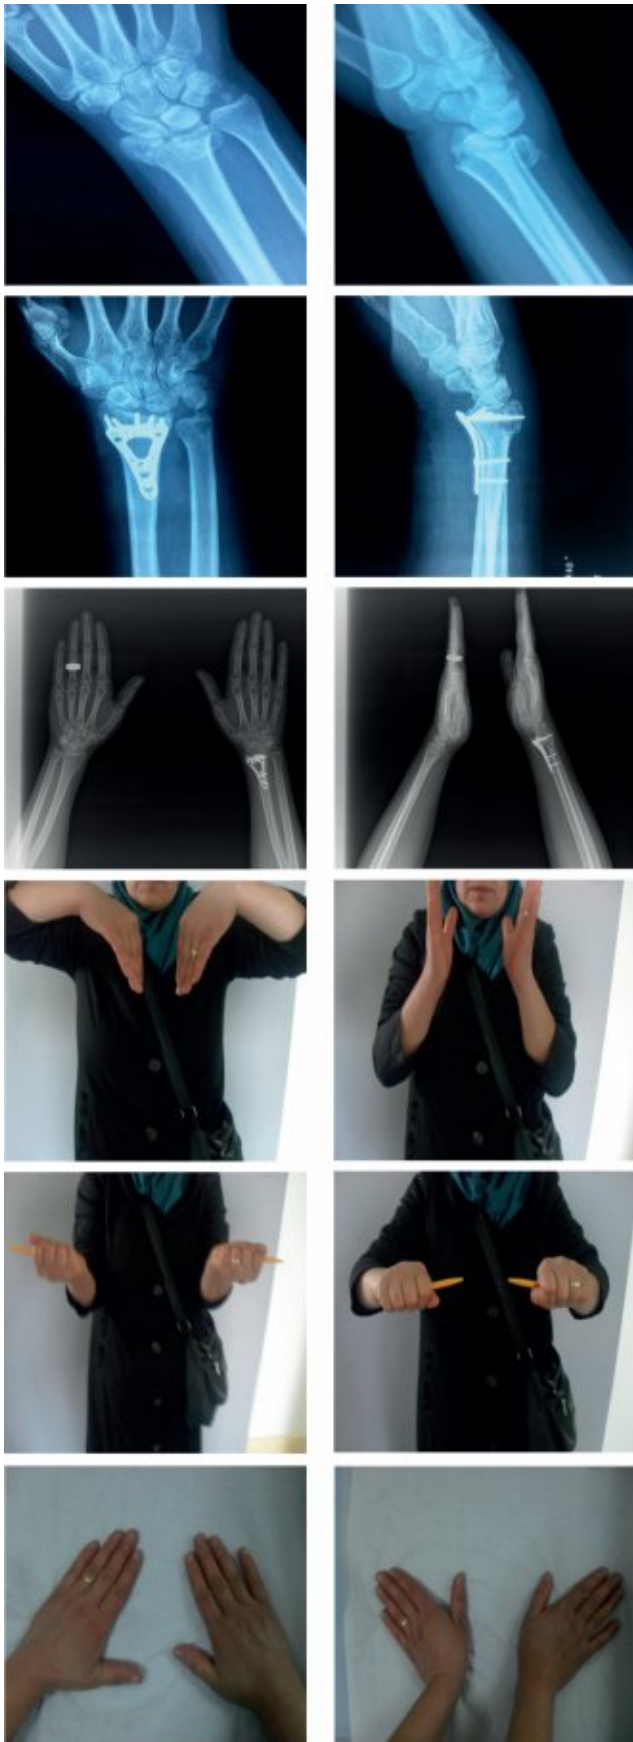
Case No: 14, ZC, age 44, woman, AO Type C3.2, before and after surgery, demonstrating the range of motion, with the final control radiography.
